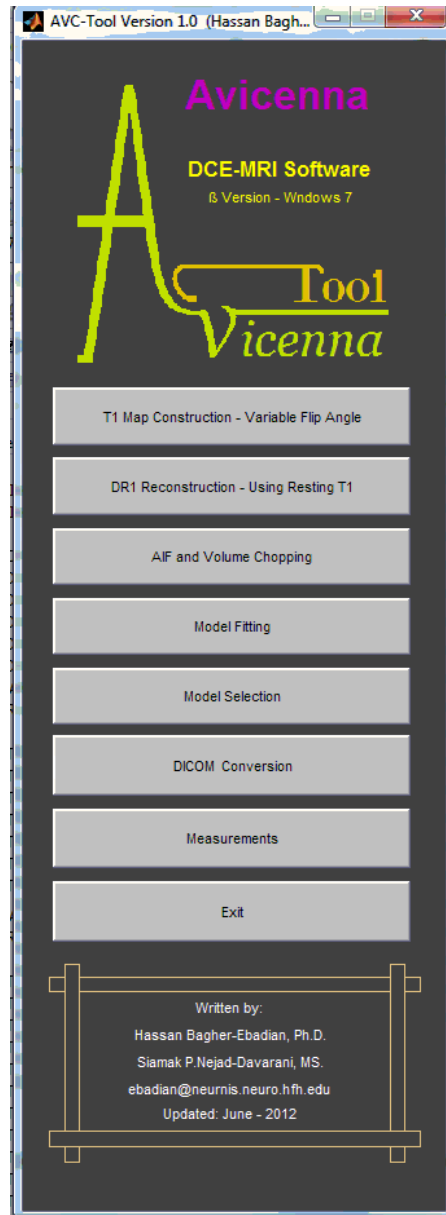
The main interface for “Avicenna” software tool. This tool is used for estimation of permeability parameters using DCE MR images.
